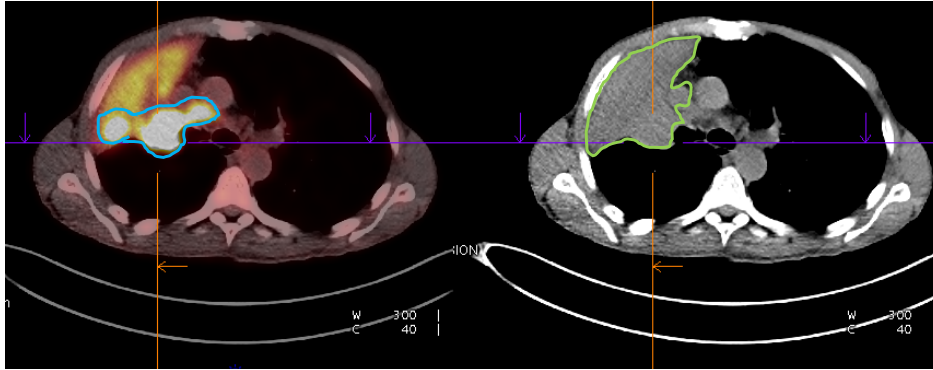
A transverse slice of a PET/CT image of the thorax using a Biograph mCT. Although the tumour mass is large, PET revealed that only a portion of the tumour mass (blue) is metabolically active in comparison to the bulk (green).
